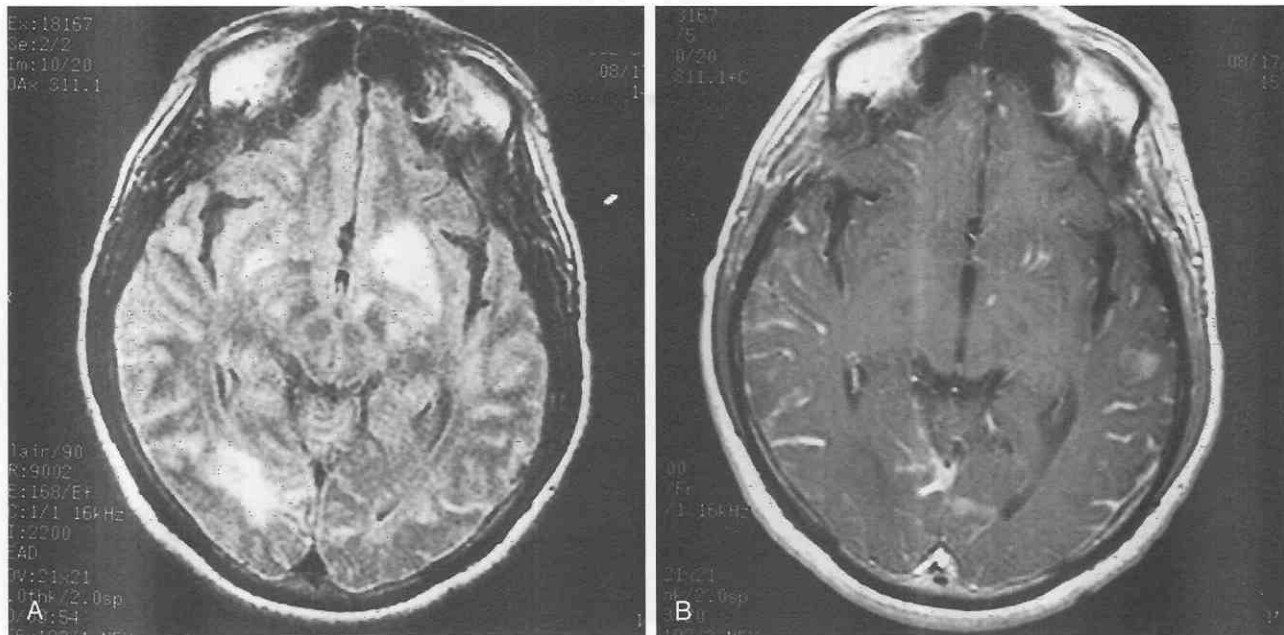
Cryptococcosis meningitis. A, Fluid-attenuating inversion recovery (FLAIR) image shows multiple high-signal areas in the basal ganglia as well as in the cortical sulci and subcortical white matter. B, Gadolinium-enhanced image demonstrates curvilinear abnormal enhancement in the basal ganglia and cortical sulci.
